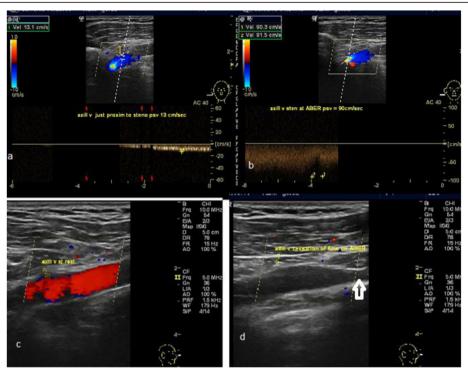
a–d Ultrasound images showing significant stenosis of the compressed vein segment at the costo-clavicular tunnel as evidenced by significant rise in the velocity ratio > 6.5 (13 cm/sec in neutral position seen in a reaching (90cm/sec in arm abduction and external rotation seen in b. c Color image for the axillary vein in the resting position but with abduction and external rotation (ABER) almost total cessation of flow was noted in d with peaked narrowing at the costo-clavicular outlet (white arrow)
